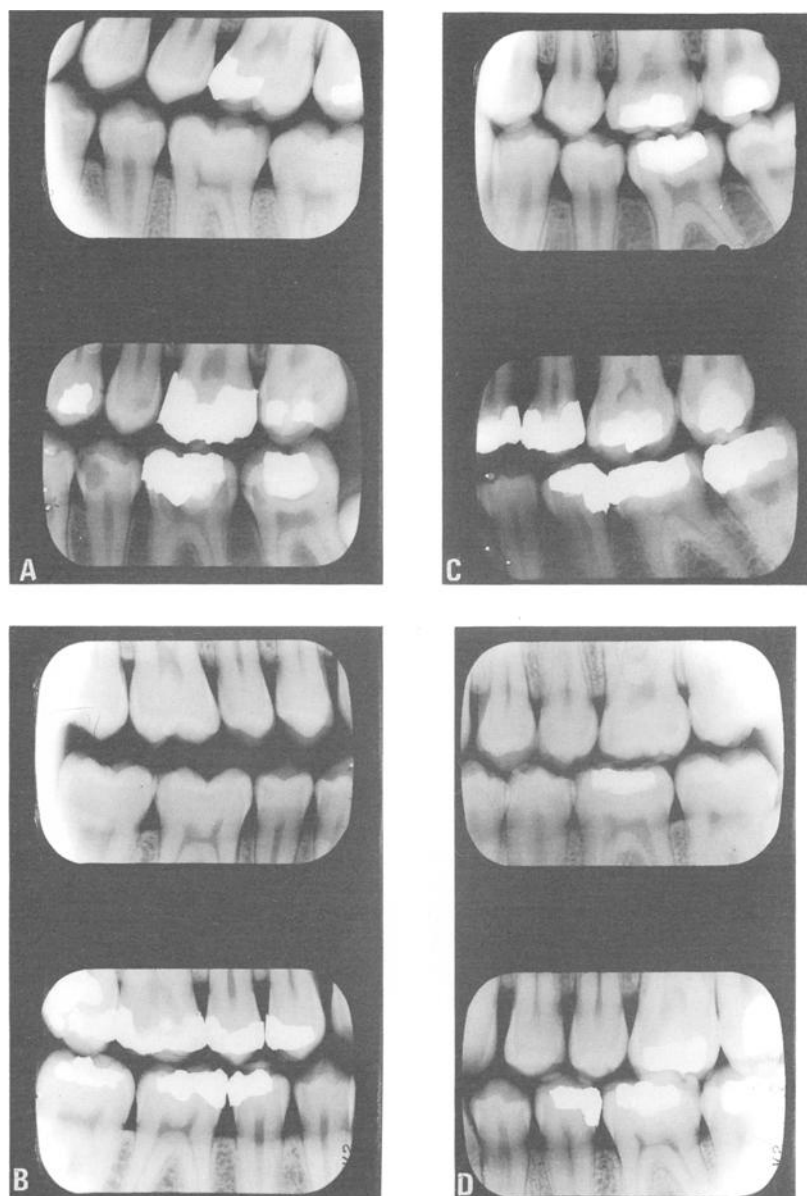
The AM/PM of bitewing pairs C and D are separated by 30 and 8 years respectively.
